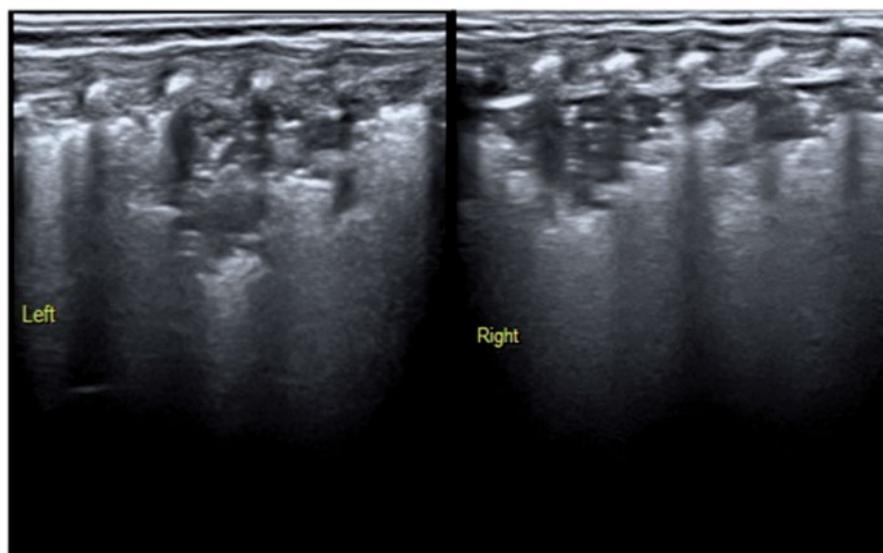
The patient was clinically diagnosed with BPD, but the ultrasound finding revealed pneumonia.
